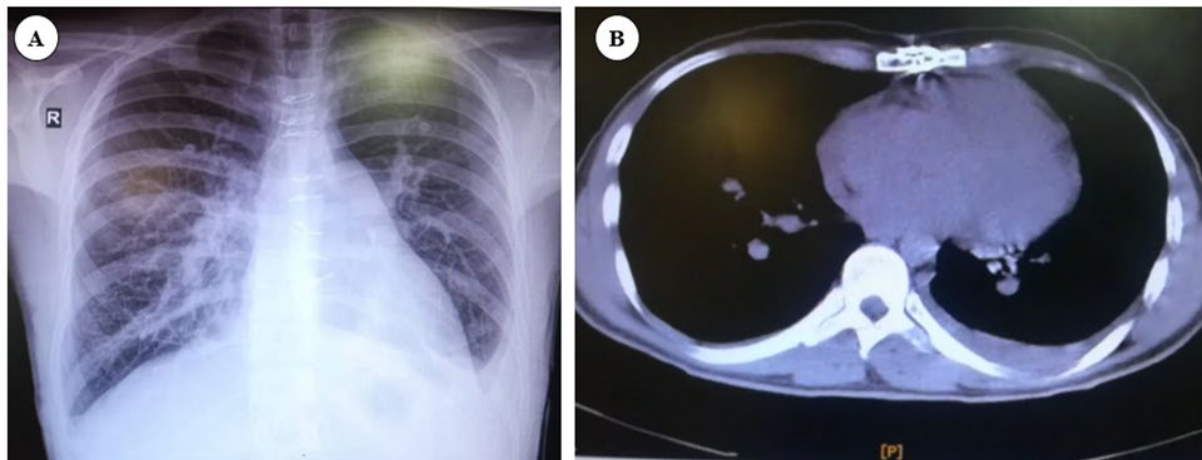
A (Chest radiography and B) Spiral chest CT scan revealing small left sided pleural effusion on the admission
